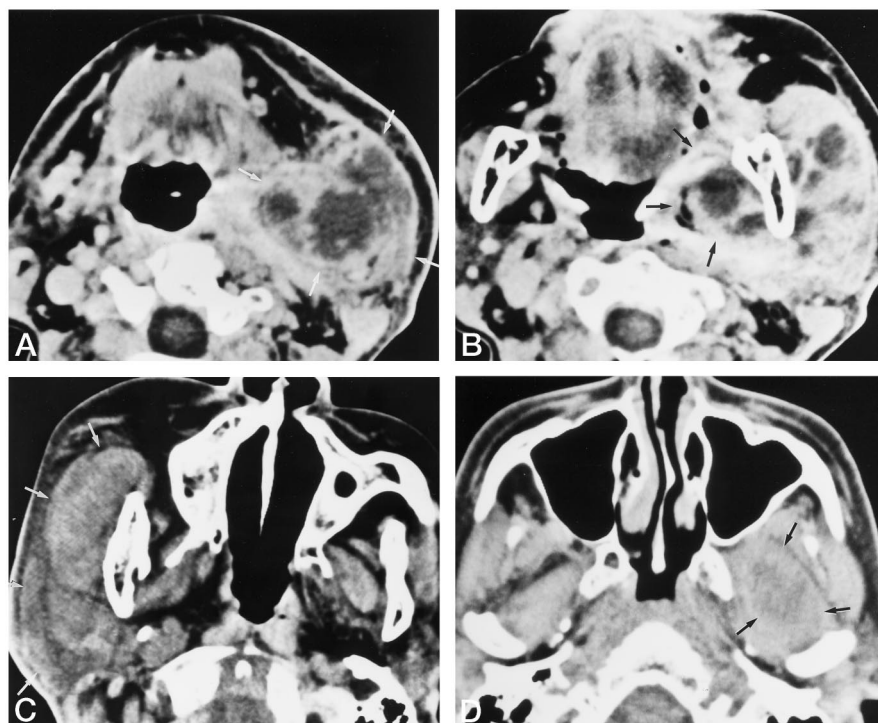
Typical CT scans of facial and neck infection of odontogenic origin (arrows indicate abscess and/or cellulitis).
